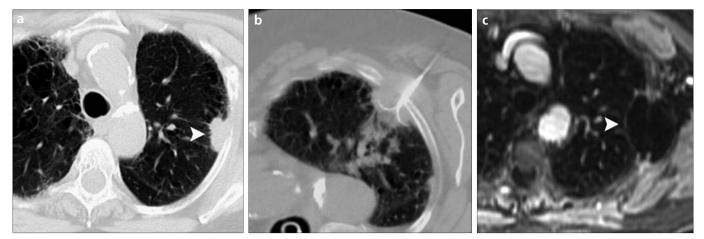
a–c. A 72-year-old woman with a biopsy-proven NSCLC, who was not a surgical candidate due to severe chronic obstructive pulmonary disease, and was referred for percutaneous RF ablation. The mass (*arrowhead*) was 2.5×2 cm in size, pleural-based, and located in the left upper lobe on CT (a). It was ablated using CT guidance and a 3 cm expandable, multi-tined RF ablation electrode (Boston Scientific Corporation) (b). RF energy was applied according to the standard vendor's protocol, starting from 40 watts and gradually increasing up to 150 watts over a total of 22 min. Follow-up MRI (c) obtained the next day showed no residual tumor (*arrowhead*) in the ablation zone. There was no recurrence at 12 months follow-up (not shown here).
